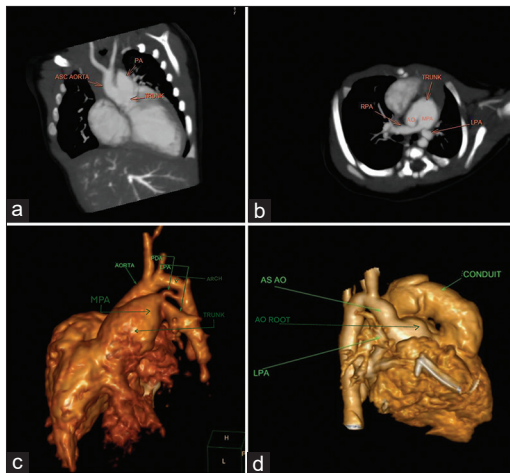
Computed tomography angiogram images showing the anatomic features before (a-c) and after (d) surgical repair of the common arterial trunk. (a) Oblique coronal view showing the common arterial trunk giving off the large main pulmonary artery and the small aorta. (b) Oblique axial view showing the common arterial trunk giving off the large main pulmonary artery and the small aorta. RPA appears to be in direct continuation of the main pulmonary artery, while the LPA origin is in a different plane. (c) Volume-rendered oblique frontal image showing all the anatomic features of this common arterial trunk-small aorta to the right of the huge main pulmonary artery, adequate aortic arch, small nonobliterate arterial duct. (d) Volume rendered oblique frontal image after surgical repair. Note the conduit to the left of aorta and the discrepancy between the neo-aortic root and the ascending aorta. Ao: Aorta, MPA: Main pulmonary artery, PDA: Patent ductus arteriosus, RPA: Right pulmonary artery, LPA: Left pulmonary artery
